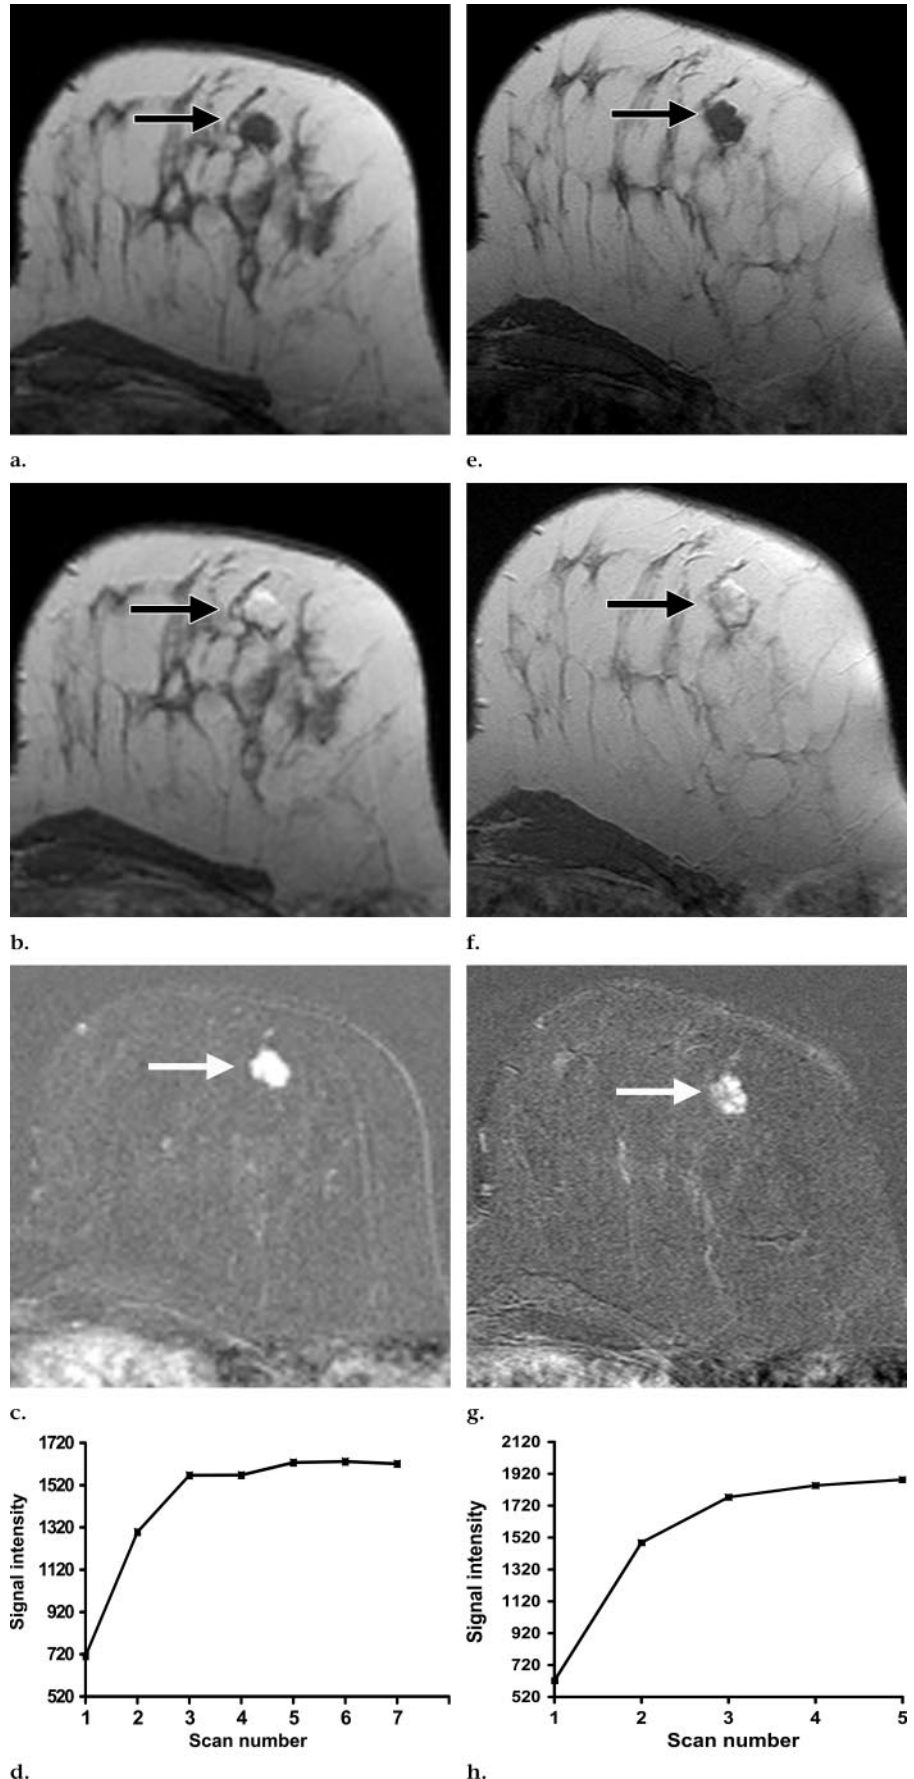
Transverse T1-weighted gradient-echo MR images (2D gradient-echo sequence, 290/4.6, and 90° flip angle) and corresponding signal intensity time course graphs for 62-year-old woman with breast cancer who underwent MR imaging for preoperative staging. (a–c) For standard dynamic protocol (256 × 256 imaging matrix with temporal resolution of 69 seconds), enhancing breast cancer (arrow in a, b, and c) appeared as irregular mass with smooth borders in (a) precontrast image, (b) first postcontrast image, and (c) first subtracted postcontrast image. (d) Graph demonstrates type 2 (plateau) signal intensity time course for standard dynamic protocol. Lesion was rated as BI-RADS category 4. (e–g) For modified dynamic protocol (400 × 512 imaging matrix with temporal resolution of 116 seconds), spicules were visualized at site of enhancing breast cancer (arrow in e, f, and g) in (e) precontrast image, (f) first postcontrast image, and (g) first subtracted postcontrast image (note the visible spicules). (h) Graph demonstrates type 3 (washout) signal intensity time course for modified dynamic protocol. Lesion was rated as BI-RADS category 5. Contrast enhancement kinetics were equivalent (strong early enhancement above threshold and plateau time course) for both protocols.
